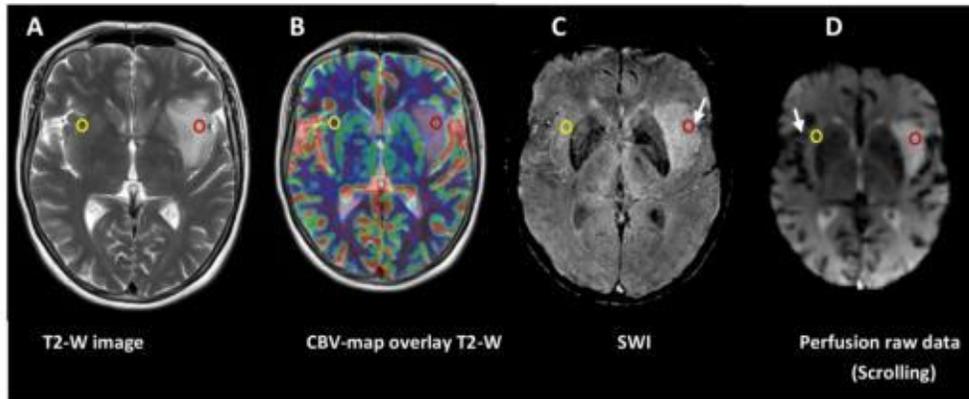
An example of the ROI placement on images of oligodendroglioma WHO grade II (a) T2-weighted image for tumor localisation (b) CBV map co-registered with T2-weighted image, where the circles point to the ROIs; red circle represents CBVmax, and yellow the contralateral white matter CBV. Adjustment of the ROI based on (c) SWI method (vessel highlighted by the white arrow in both sides) and (d) Scrolling method (the presence of vessel was found in one side of the brain in this case).
